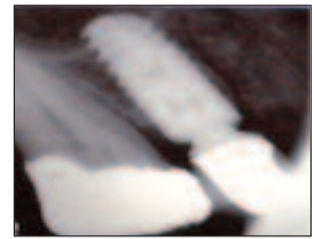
Final radiograph of the definitive implant-supported restoration
